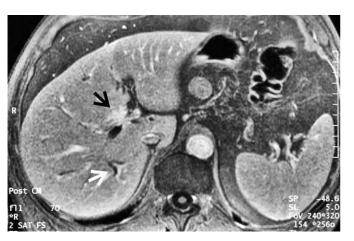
Abdominal magnetic resonance imaging (MRI) showed a hilar-located contrast-enhanced mass in the liver (20 mm diameter; black arrow), causing stricture of the ducti hepatici and intrahepatic cholestasis (white arrow).
